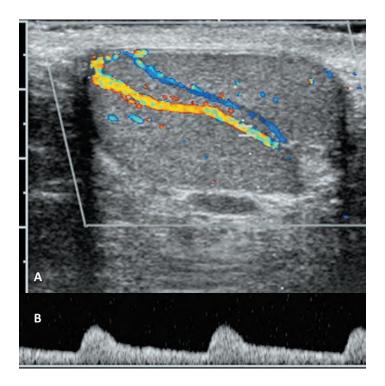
A. Color Doppler of normal intratesticular artery. B. Spectral Doppler waveform of normal intratesticular artery reveals low-impedance pattern with continuous diastolic forward flow.
